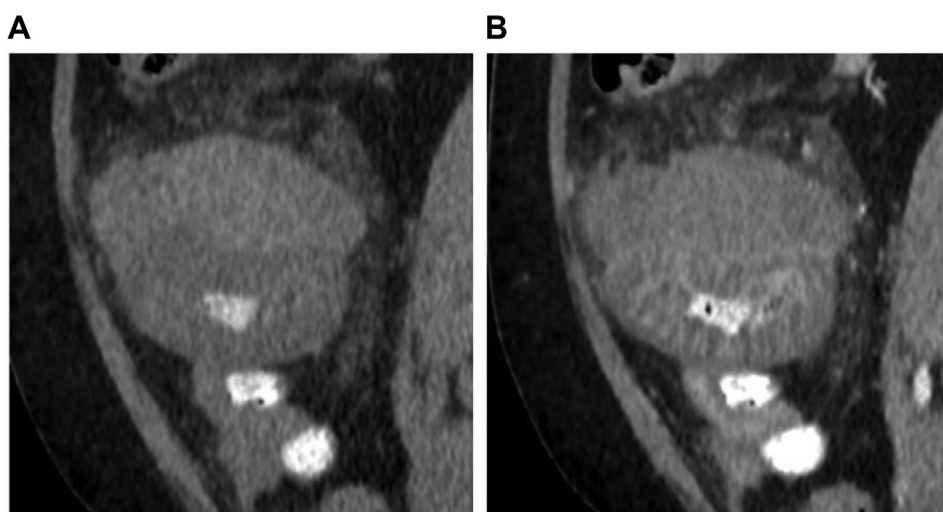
Sagittal plain (A) and contrast (B) CT images show the mesenteric lesion with surrounding fat stranding and mildly dilated, enhancing bowel loop with reduced luminal calibre.
